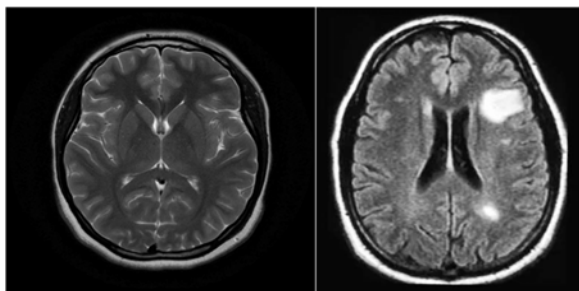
Difference between a normal MRI (left) and a MRI of a Multiple Sclerosis patient (right).
